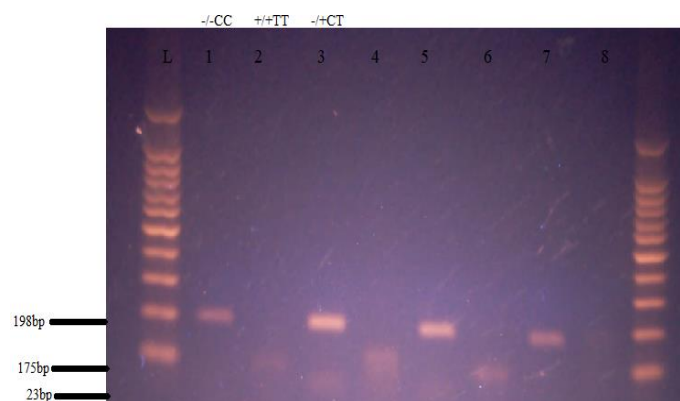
Genotyping of case families revealed by digestion of pcr products by *Hinf* I L, 100bp ladder, lane 1: -/-CC wild type, lane 2: +/+TT homozygous, lane 3: -/+CT heterozygous
